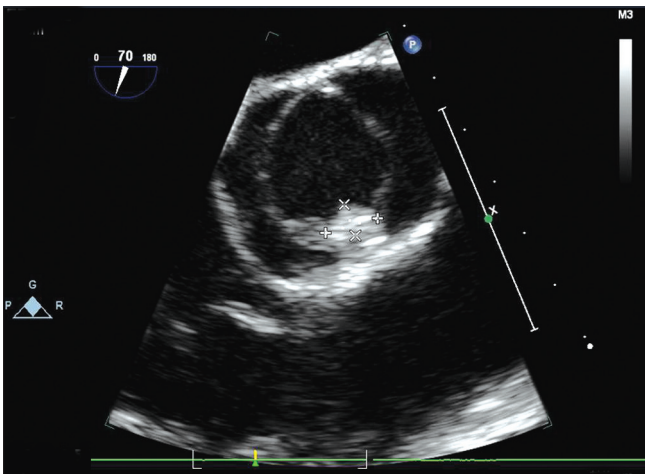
Transesophageal echocardiography showing a vegetation attached to the anterior commissure in the 5 "O" clock position
